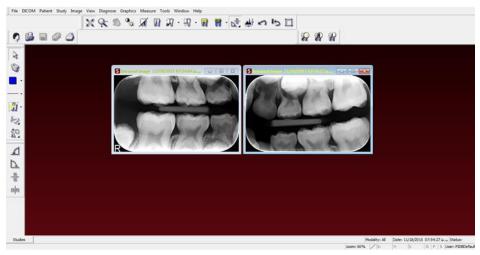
Bitewing Radiography
